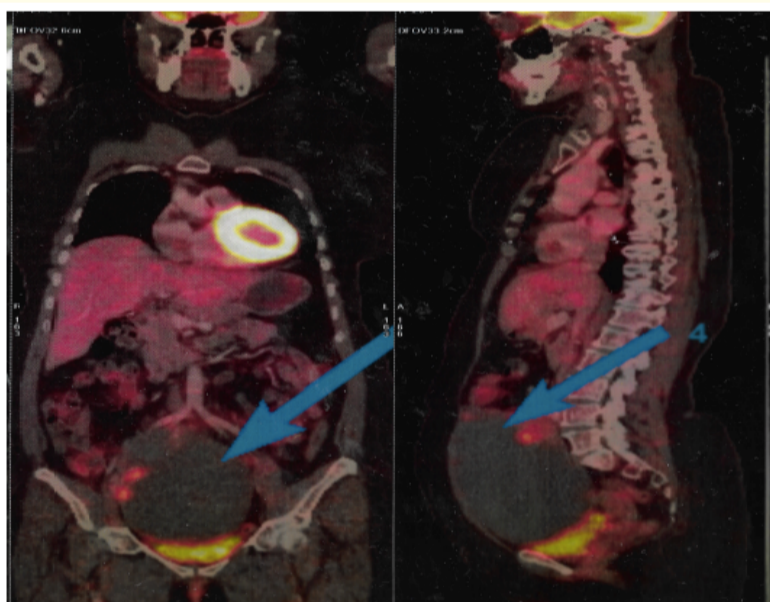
PET-CT showing a well-circumscribed thin-walled solid-cystic lesion showing contrast enhancement and FDG avidity.
